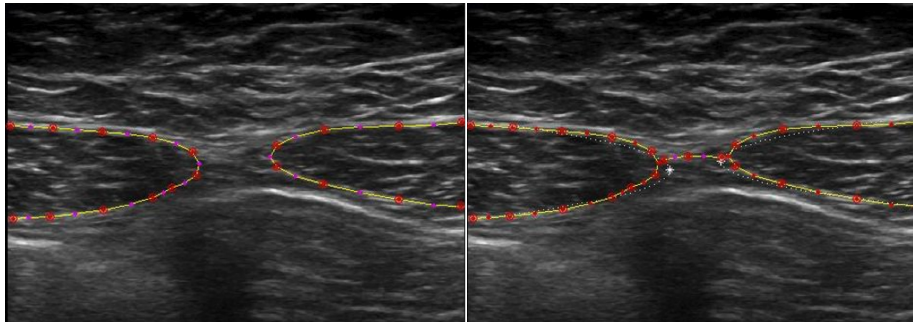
2 A. Rectus abdominis (both) ultrasound image. B. Points digitalized by the examiner on the muscles contour (red dots). Interpolated points are using an algorithm according to a parabola-shape like curve (white points); parabola inflexion point (white asterisk) suggesting the end-points for IRD measurement on the medial margin of both rectus abdominis.
